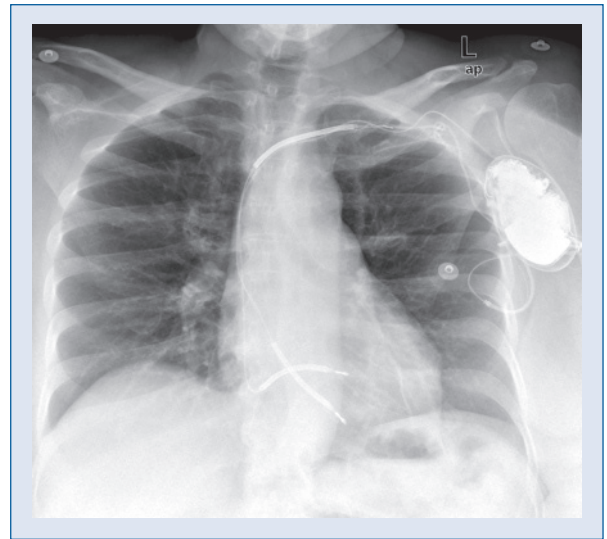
Postoperative chest X-ray showing new defibrillation lead in place.
